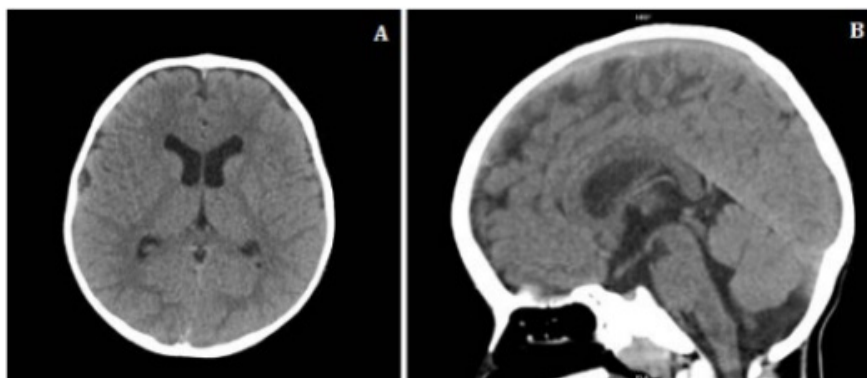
Baseline cranial computed tomography of a 2-year-old male patient. Panel A shows the axial view and Panel B the sagittal view. The examination demonstrates preserved gray–white matter differentiation, no supratentorial parenchymal alteration, normal ventricular morphology, absence of extra-axial collections, and a posterior fossa appearance without evident gross structural distortion in this section
